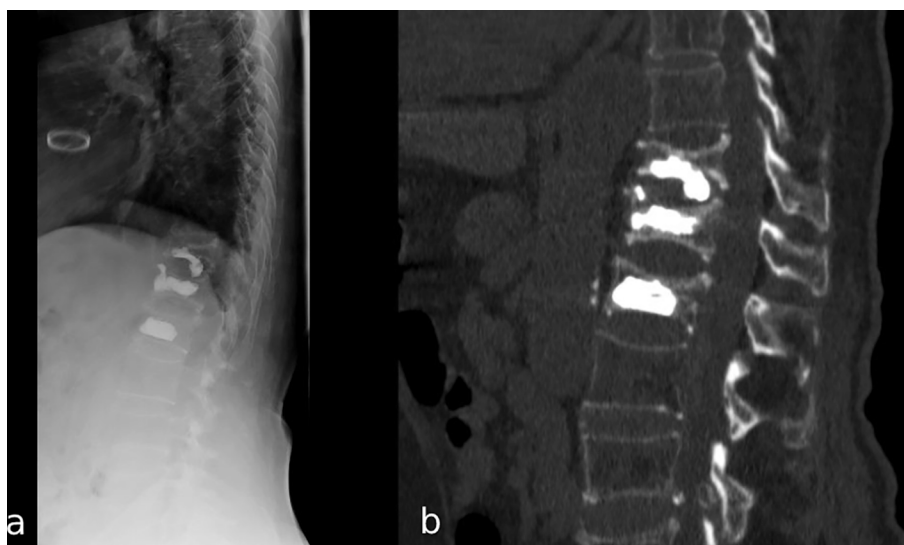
Sagittal plane thoracolumbar X-ray (a) and CT scan, (b) after kyphoplasty.
